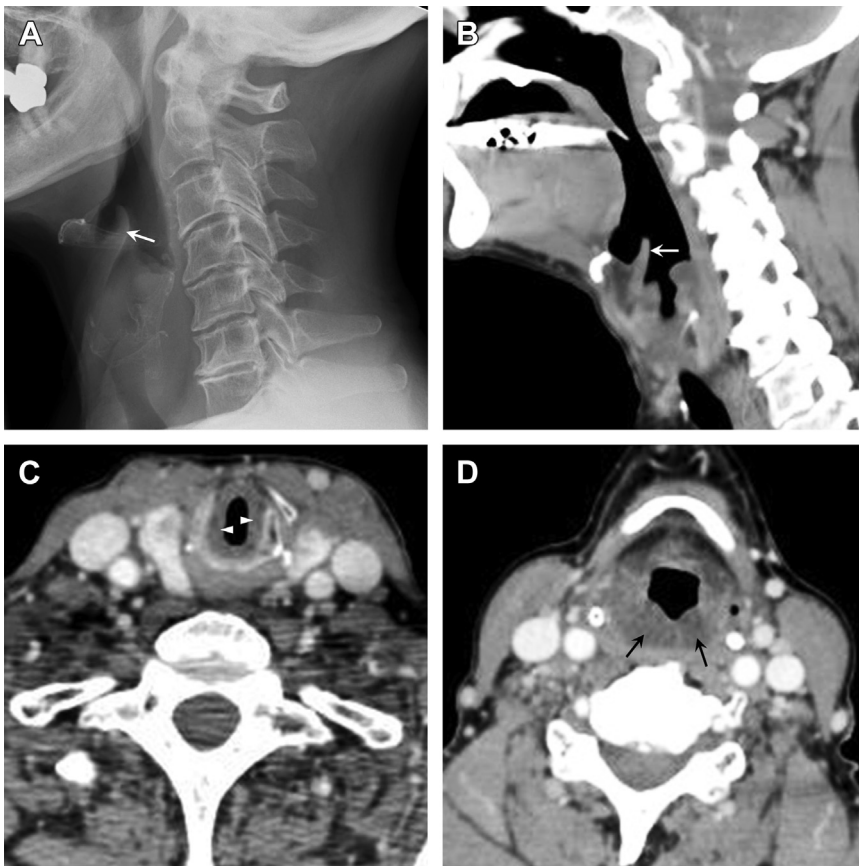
Acute supraglottitis and laryngitis: (A) Lateral radiograph demonstrates enlargement of the suprahoid and infrahyoid epiglottis (*white arrow*). Sagittal (B) and axial (C, D) Computed tomography scans also reveal edema of the epiglottis (*white arrow*), aryepiglottic folds (*black arrows*), and mucosal lining of the subglottic larynx (*white arrowheads*).
